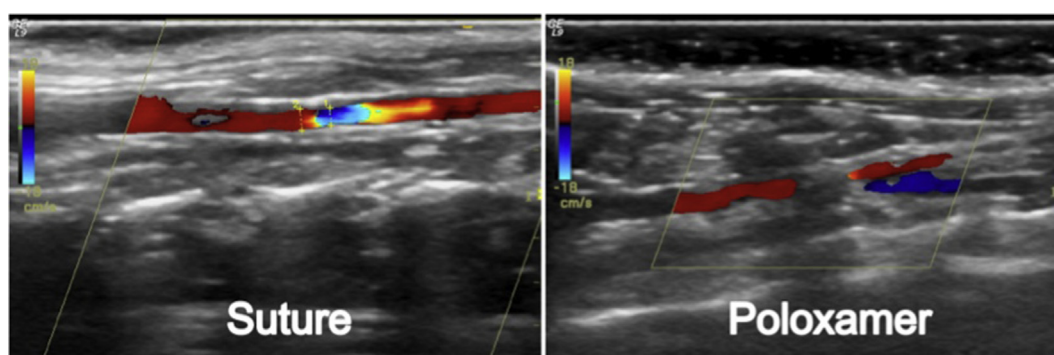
Anastomoses sites are shown with Doppler ultrasound.
